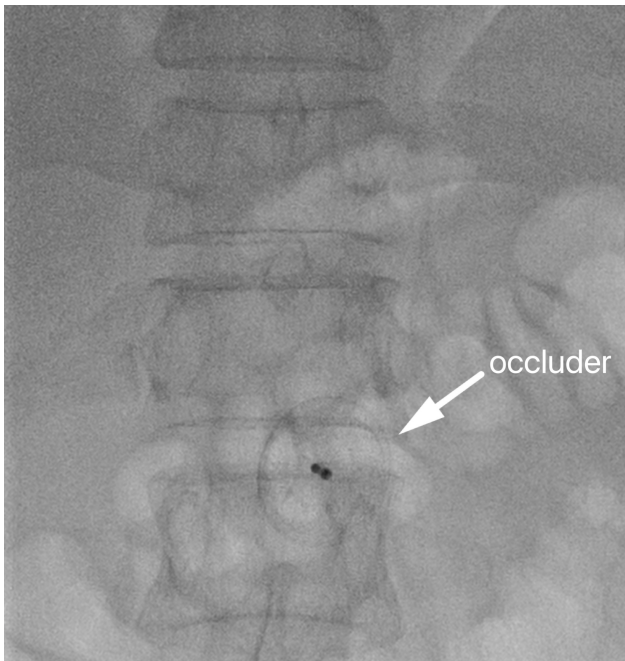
Chest X-ray suggested that the occluder fell to the abdominal aorta.
